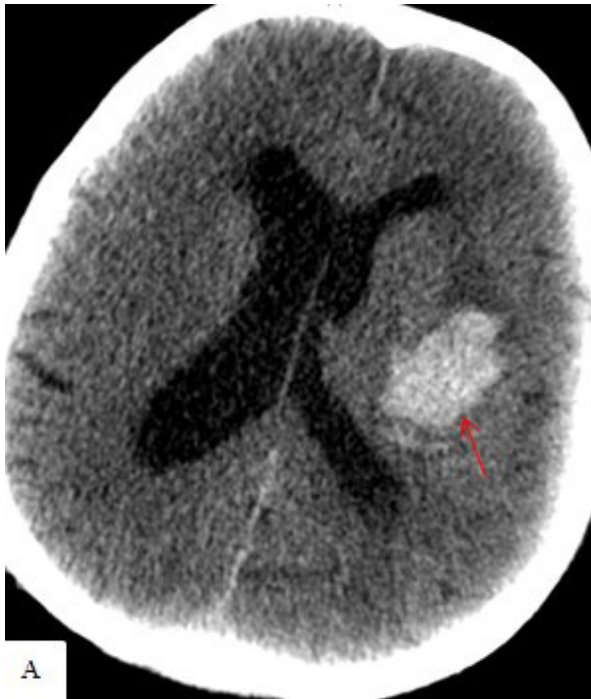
A 60-year-old male patient presented with COVID-19 pneumonia and followed in ICU with anticoagulation treatment. Parenchymal window axial CT image shows acute left thalamic cerebral hematoma (arrow)
